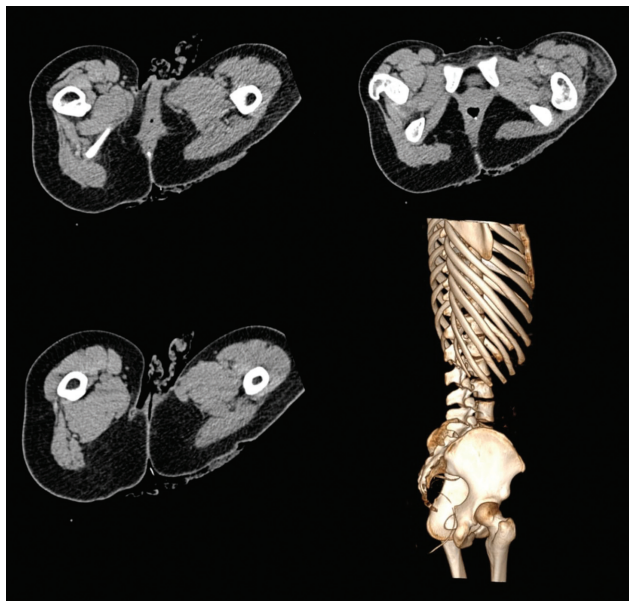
Abdomen computed tomography scan, after the surgery to remove the proximal portion of the ventriculoperitoneal shunt and to implant an external ventricular drain (seven days later), showing the peritoneal catheter being extruded through the patient's anus.
